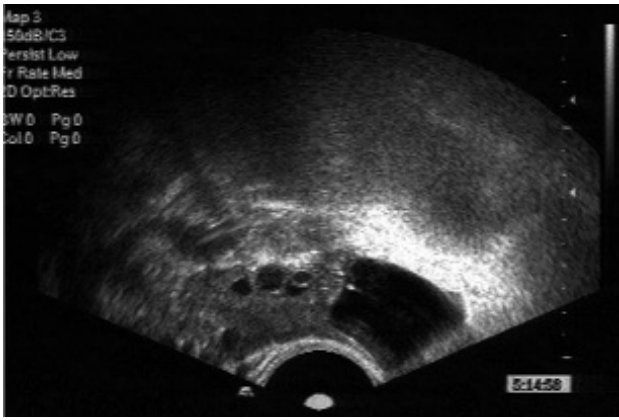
Typical appearance of a hydrosalpinx beside the ovary at transvaginal ultrasound investigation.
